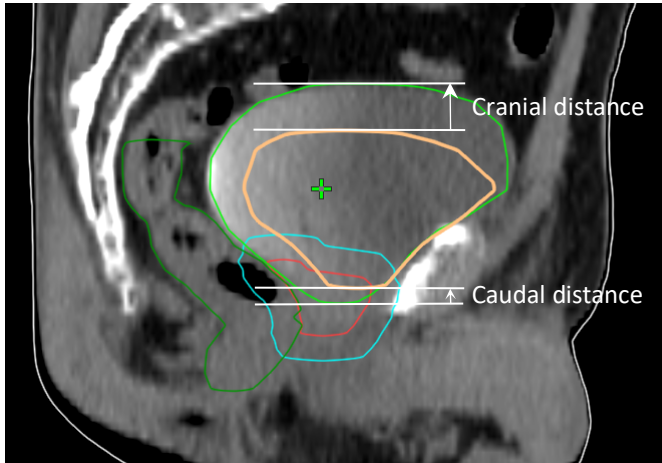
An example of pCT and CBCT images in a sagittal view matched and stored on top of each other. Colors indicate the following: bladder (green and orange), CTV (red), PTV (blue). Distance in the two-dimensional direction between different bladder volumes was measured cranially and caudally, arrow indicating positive (+) measurement.
